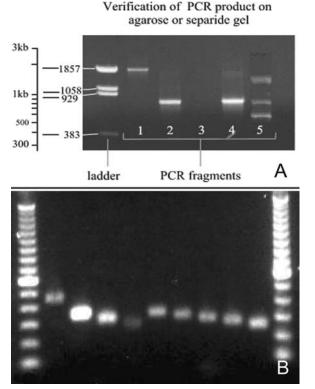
Electrophoretic gel separation of PCR-generated DNA sequences. (A) Sequence fragments that have the same nucleic acid sequence will migrate the same distance through the gel. (B) Even a single nucleic acid variation (addition, substitution, or deletion) will cause the PCR fragment to assume a different spatial configuration, resulting in a change in how far the segment will travel through the gel. (Courtesy of Dr. O. Henegariu, New Haven, CT.)
